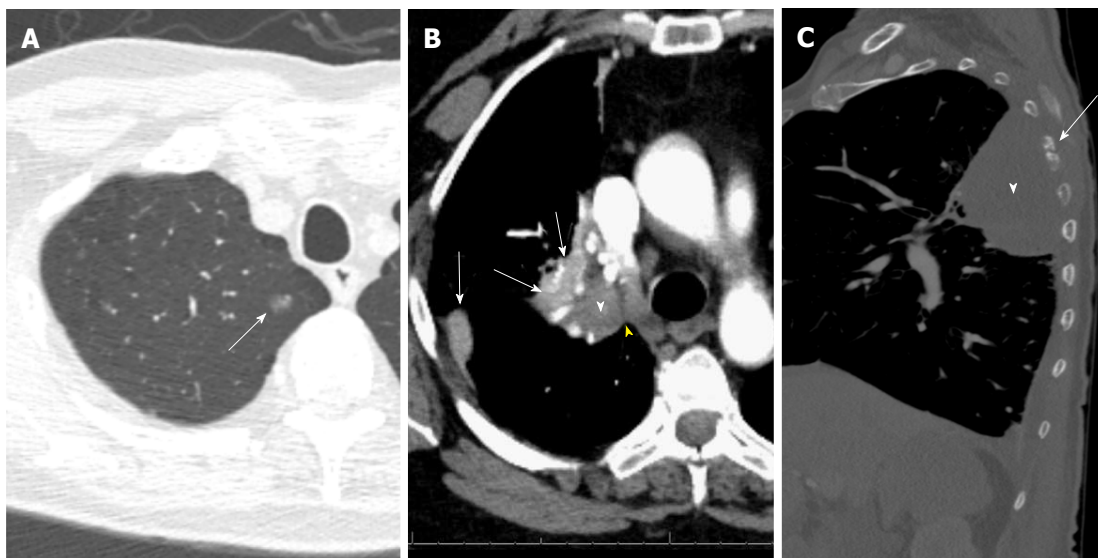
T descriptors. A: T1a (mi): Groundglass opacity in the apical segment of the right upper lobe (arrow) on CT lung window image; resection revealed predominantly lepidic adenocarcinoma with 3-mm invasive component and clear margins; B: T2a: 4-cm invasive squamous cell bronchogenic carcinoma of the right upper lobar bronchus (white arrowhead) with adjacent areas of atelectasis (arrows) and clear cleavage plane with the mediastinum (yellow arrowhead) on contrast-enhanced CT image; C: T4 vs T3: 8.3cm left upper lobe mass (white arrowhead), with chest wall invasion causing destruction of the adjacent left 5th rib (arrow) and small left pleural effusion. Note that the highest descriptor should be used for T staging.
